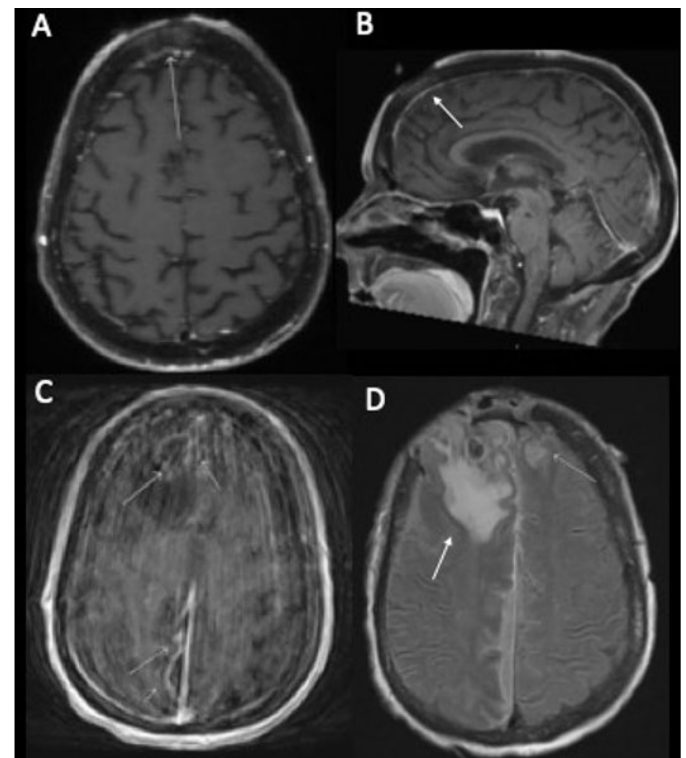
Evolution of the forehead lesion on magnetic resonance imaging (MRI) of the brain. (A) T1 axial image completed one month prior to presentation with a roughly 2 cm area reflecting early osteonecrotic changes. (B) T1 sagittal image completed one month prior to presentation with a 2.5 cm defect in the right anterior vertex scalp. (C) Upon presentation, T1 axial image revealed a faint ring enhancement in the right frontal lobe concerning for early brain abscess along with right parafalcine and tentorial subdural empyema. (D) Post-operative T2 coronal image with persistent surrounding vasogenic edema with frontal lobe herniation and left parasagittal frontal lobe focus of hemorrhagic cerebritis.
